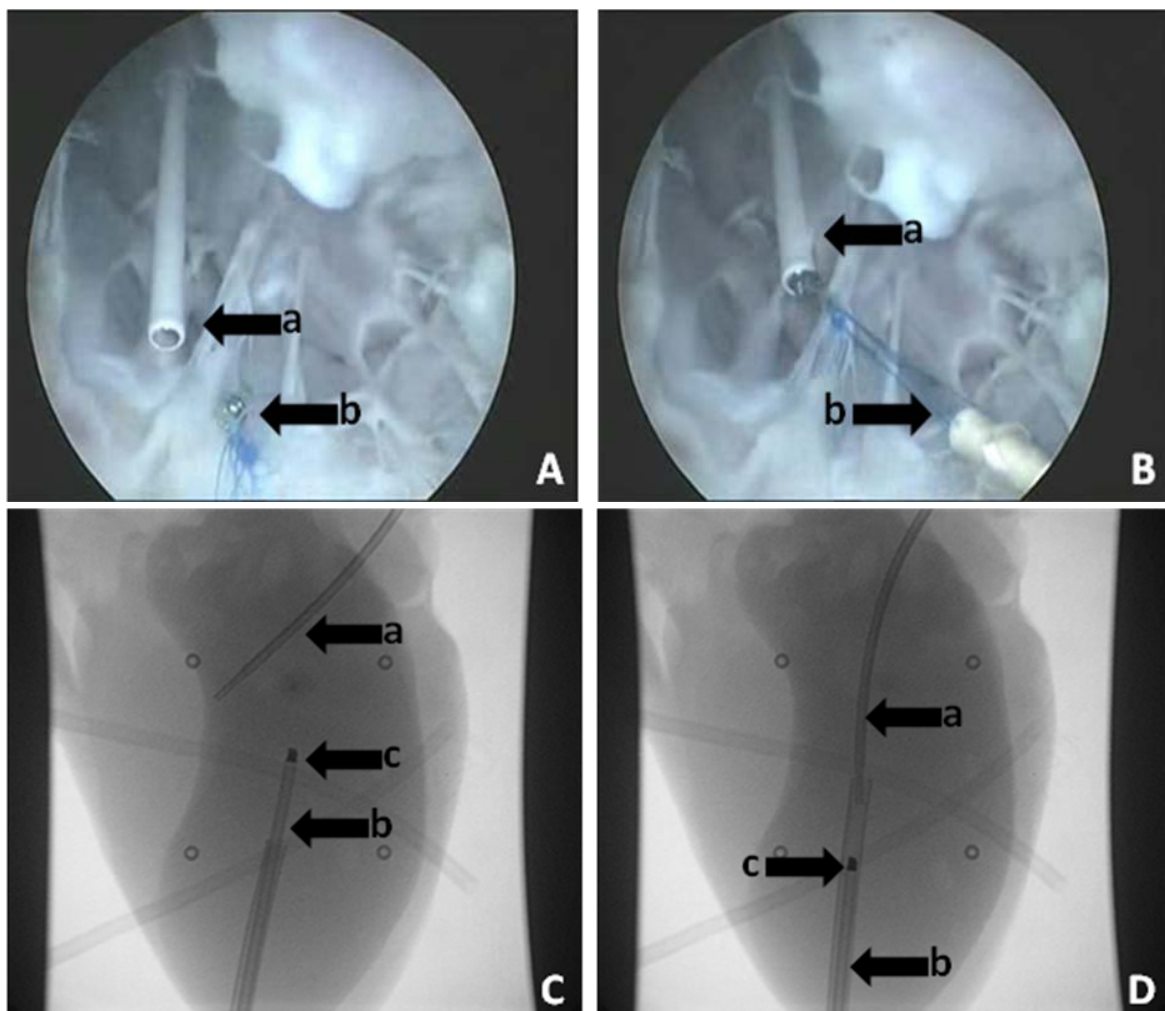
A, B: The magnets caught each other under endoscopic view. (a: the stick with the magnet on the tip; b: the magnet on the tip of the balloon catheter). C, D: The magnet capture was successfully performed under X-ray visualization. (a: the balloon catheter; b: the capture stick; c: the magnets).
